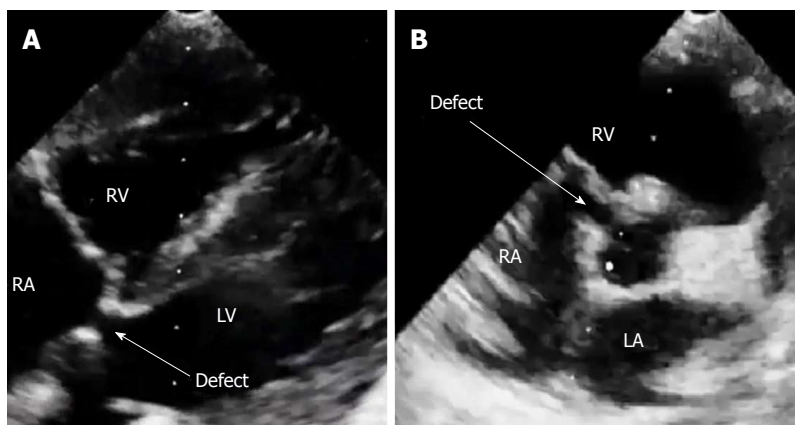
The Gerbode defect were best seen on echocardiography at subcostal five chamber view (A) or parasternal short axis view (B).
